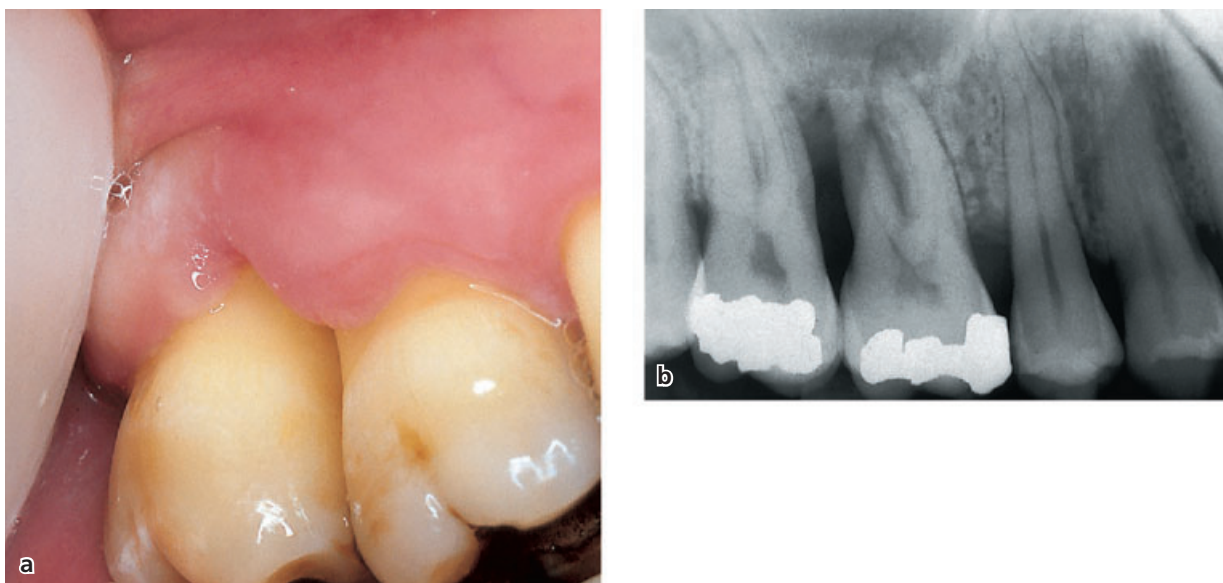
(a) Necrotizing periodontitis often results in major loss of interdental tissue including alveolar bone of the molar regions as demonstrated in the radiograph (b).
